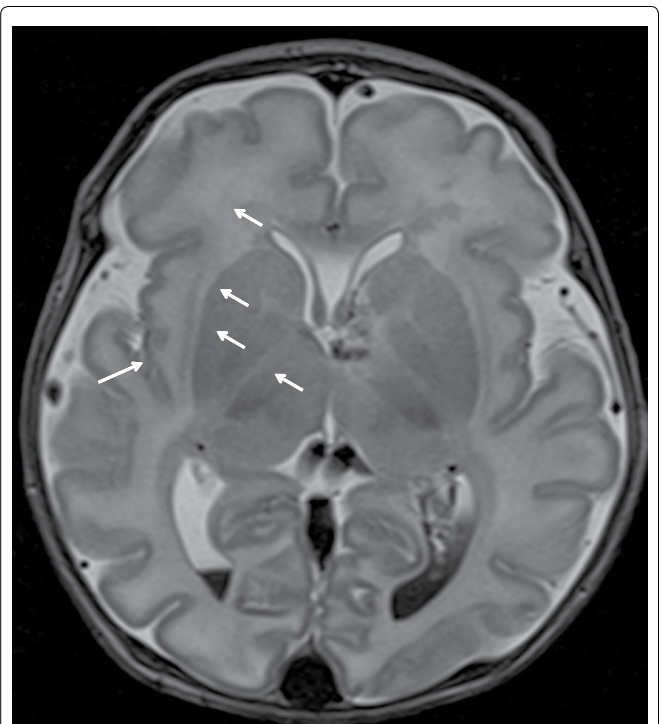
The transversal T2-weighted image of the head shows hypointense blood level intraventricular, a hemorrhage in the basal ganglia and a thrombus with low intensity in the superior sagittal sinus, vena galena and venae cerebri interna.
